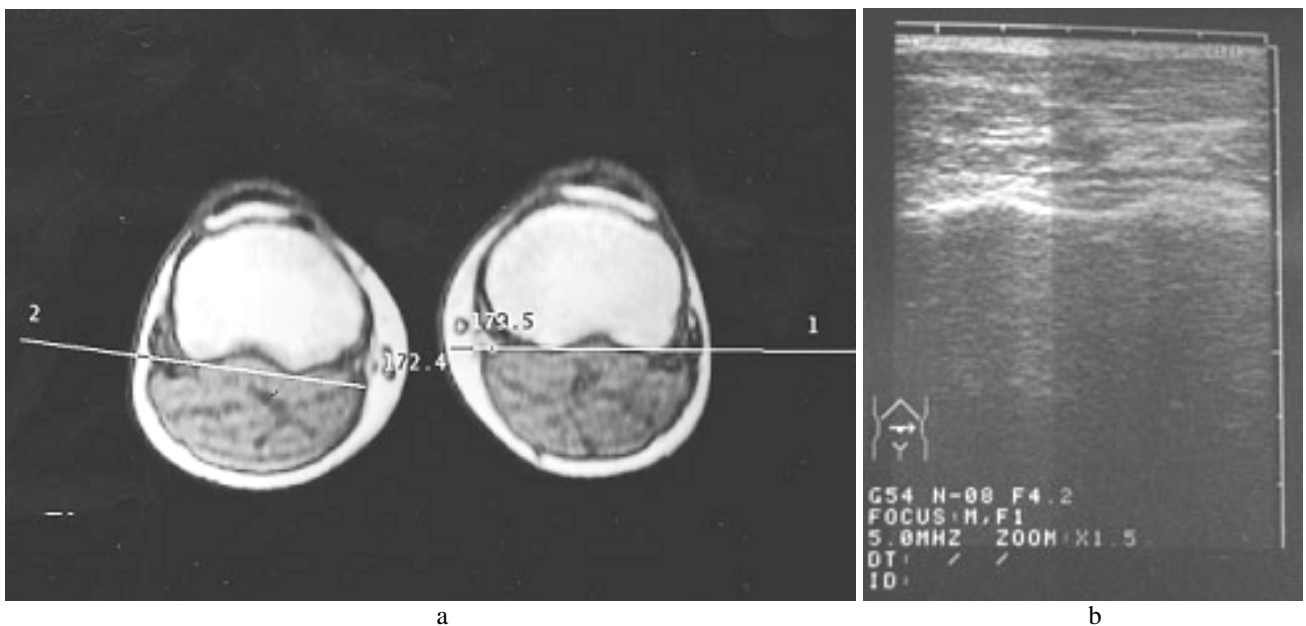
Proximal reference line determination by CT (a) and photoplantography (2b) methods
